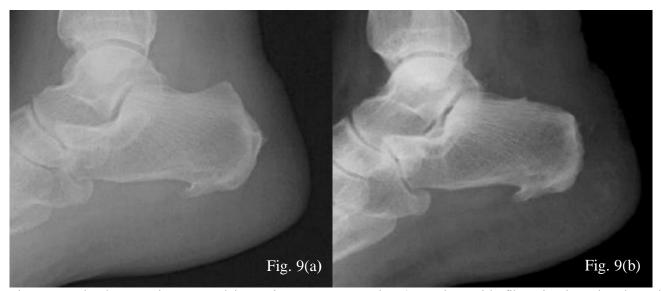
Haglund's prominence excision using a rongeur; Fig. 6: Anchor with fibrewire insertion into the posterior tubercule of the calcaneus; Fig. 7: Tied first and second leg of the suture; Fig. 8: Achilles tendon repaired with the knots buried inside; Fig. 9: (a) Pre-op vs (b) post-op radiograph of one of our patient
